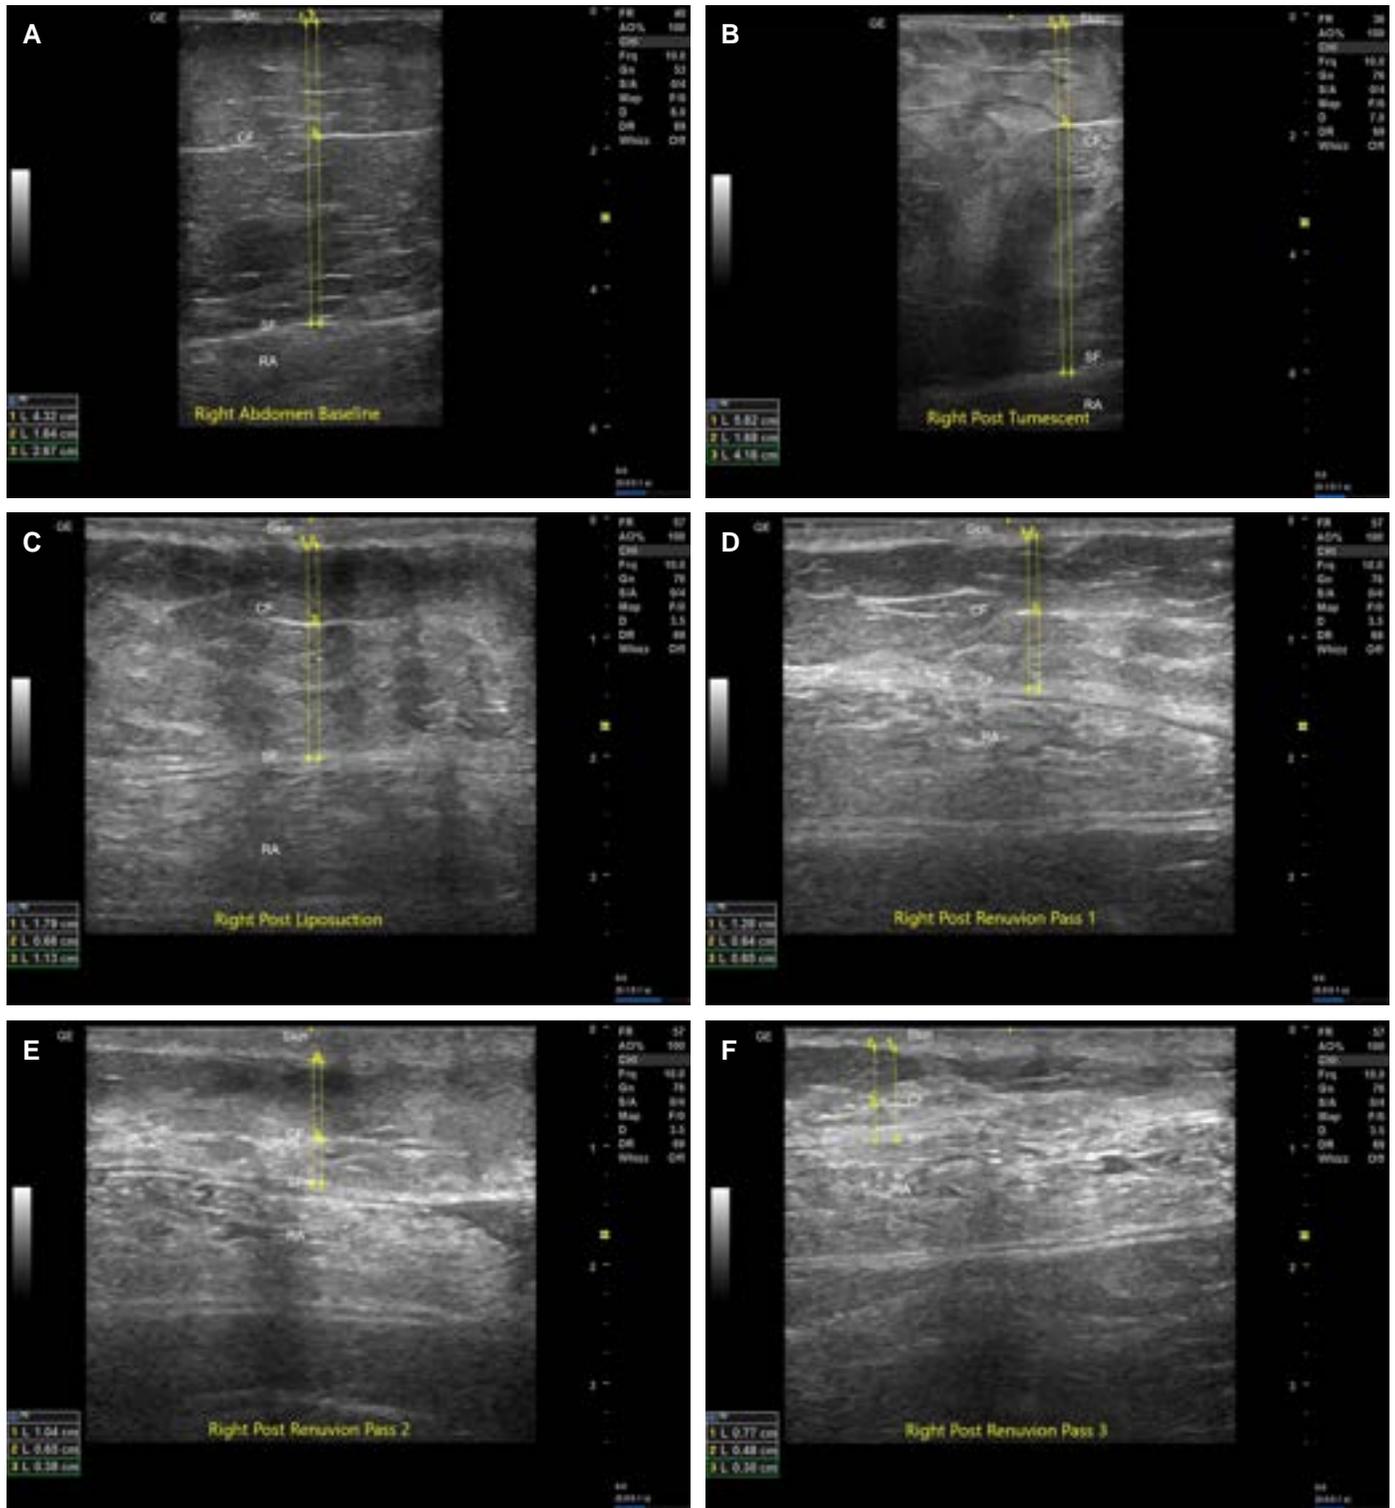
Example ultrasound images showing the change in the right abdomen: baseline (A), after tumescent (B), after liposuction (C), and after helium plasma radiofrequency Pass 1 (D), Pass 2 (E), Pass 3 (F), and Pass 4 (G). Camper's fascia (CF), Scamper's fascia (SF), and the rectus abdominis muscle (RA) are labeled.
